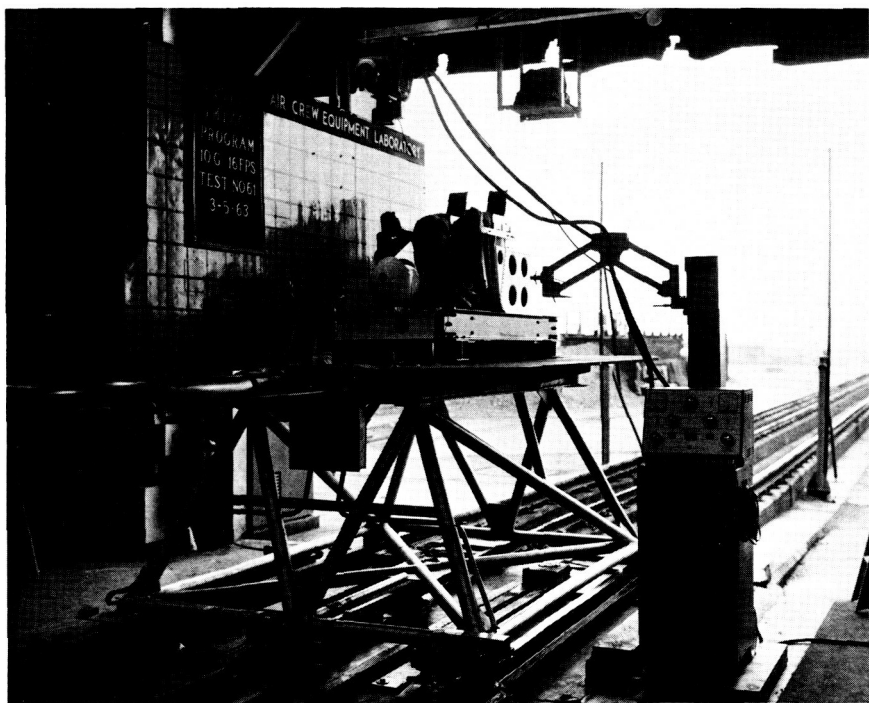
Horizontal linear accelerator for application of negative impact accelerations to supine subjects. View shows equipment for obtaining X-rays of subjects during acceleration event.
